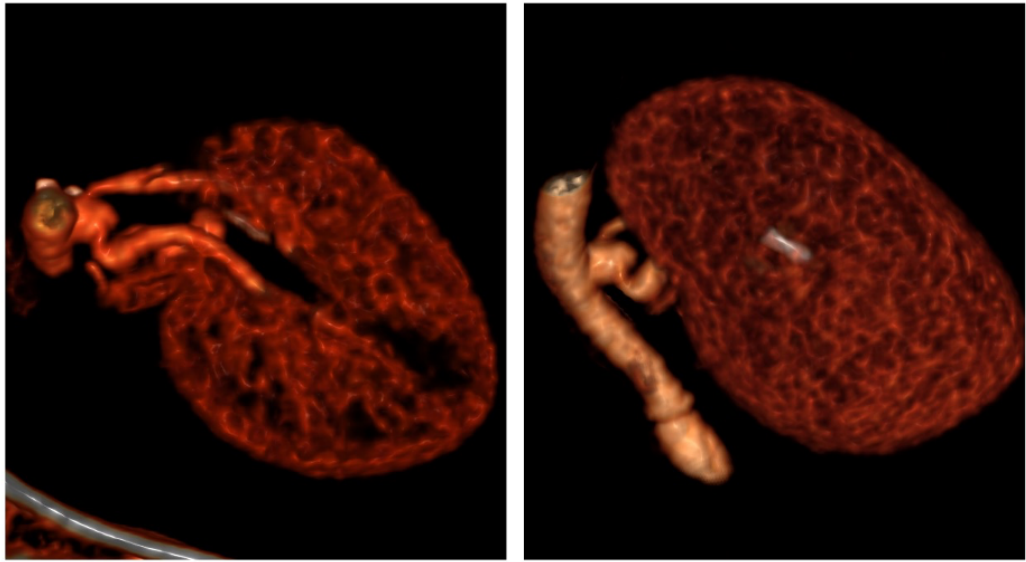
Multiplanar volume reconstruction images of the post-transplant CT angiogram demonstrating the two branches emerging from the common stem.
